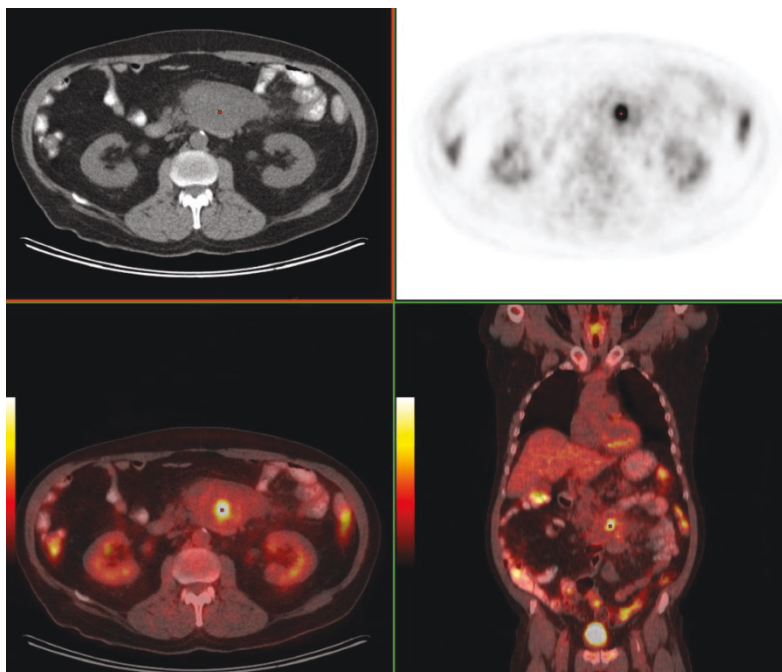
[18F] FDG PET scan after chemotherapy demonstrating the residual mesenteric mass with a central area of viable tumor. Even if a needle biopsy were performed there was a good chance of missing the viable tissue.
